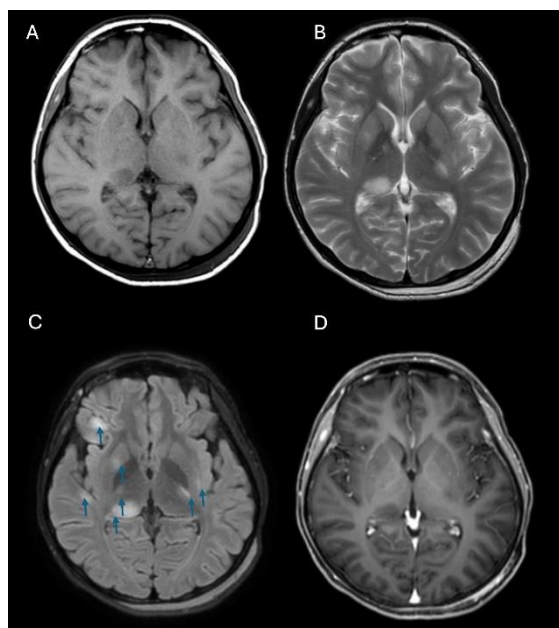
MRI Brain shows abnormal signal intensity involving cortical and deep gray matter (arrows). Hypointense on T1W (A), hyperintense on T2W (B), prominent on FLAIR (B) and not enhancing in contrasted sequence (C)
